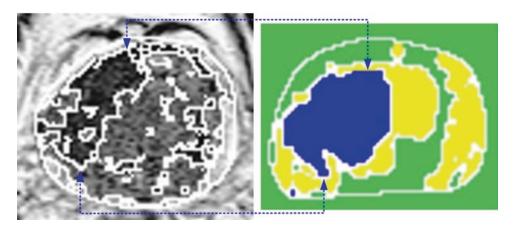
Correlating HCS boundary outlined T2-weighted image (*left*) with the DCE-MRI TIC-based classified regions (*right*). The loss of signal in the T2-weighted image (*left*) matches with the DCE-MRI T2 region classified as carcinoma (*Blue region*), based on the six different types of enhancement patterns (Fig. 16)
